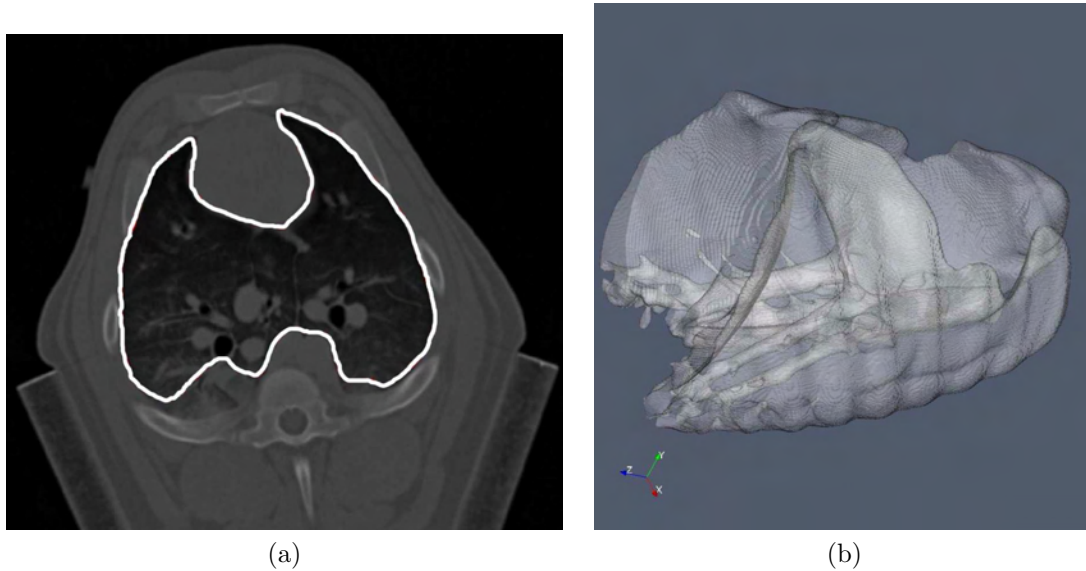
Segmentation of lung region from CT data set (a) slice and (b) volume rendering of segmented region.
